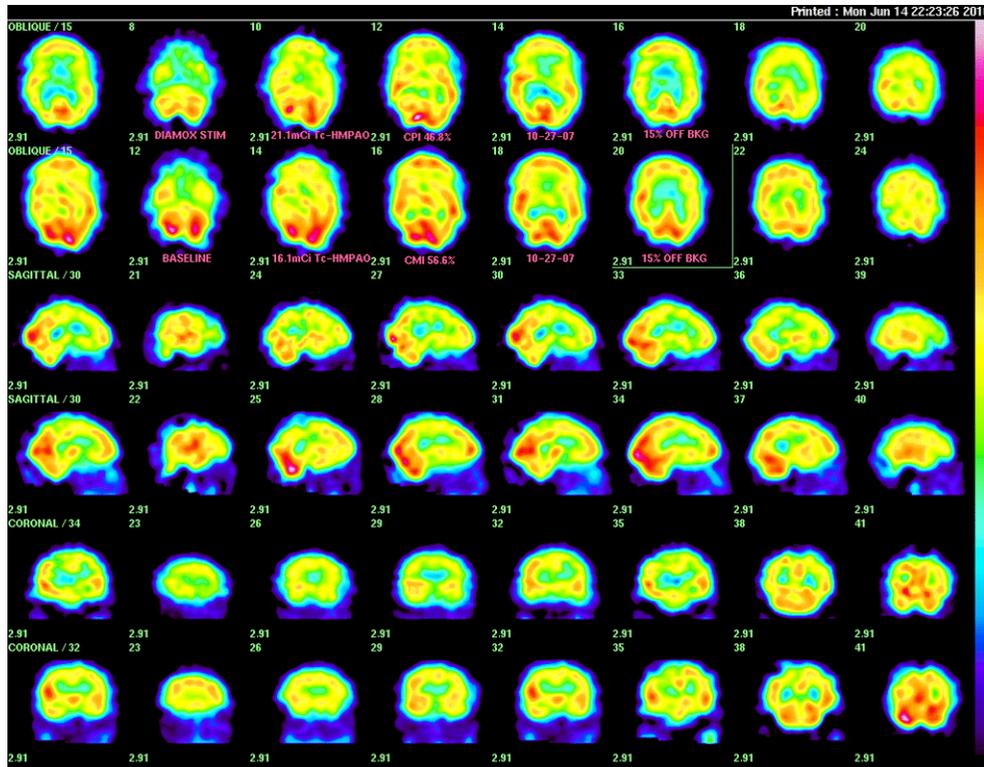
Above are SPECT images for a 71 year-old hypogonadal, type 2 diabetic man with hypothalamic hypoperfusion and stable renal insufficiency, GFR (46.4+-3) ml/min over 2 years, whose CR (46.8-56.6)% < 3 is also abnormal. Of a total of 4 pituitary patients with renal insufficiency, 75% (3/4) were exceptions to the usual observation of normal CR, these 3 together with 10 scans in 8 stroke patients (one of whom had pituitary apoplexy) accounting for 13/19 = 68.4% of the total number of such atypical cases.
